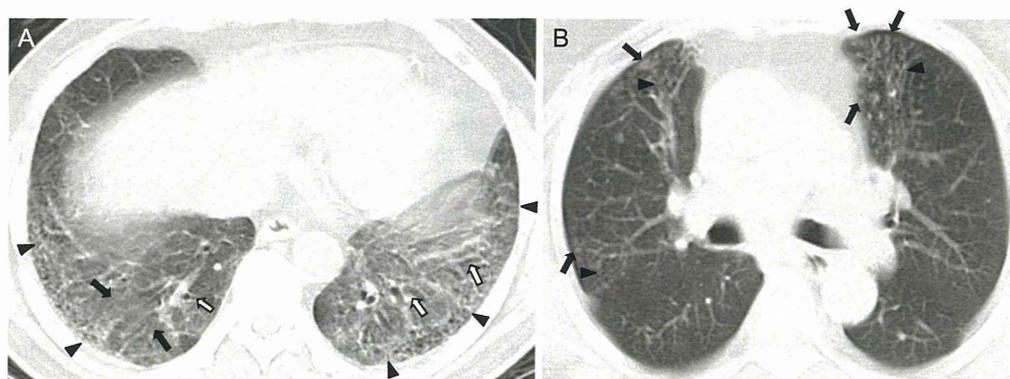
(A) A transverse CT scan from a 60-year-old man with a categorized NSIP pattern showing peripheral ground-glass opacity (black arrow), a reticular shadow (black arrowhead) and traction bronchiectasis (white arrow). (B) A transverse CT scan from a 71-year-old woman with a categorized DPB pattern showing centrilobular nodules (black arrow) and dilated proximal bronchi (black arrowhead).
